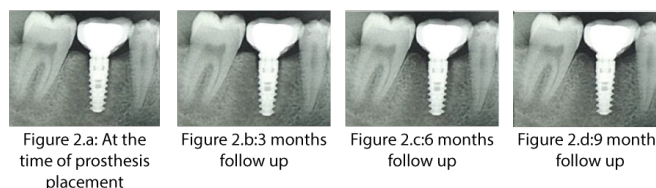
Radiographic status of screw retained implant prosthesis
